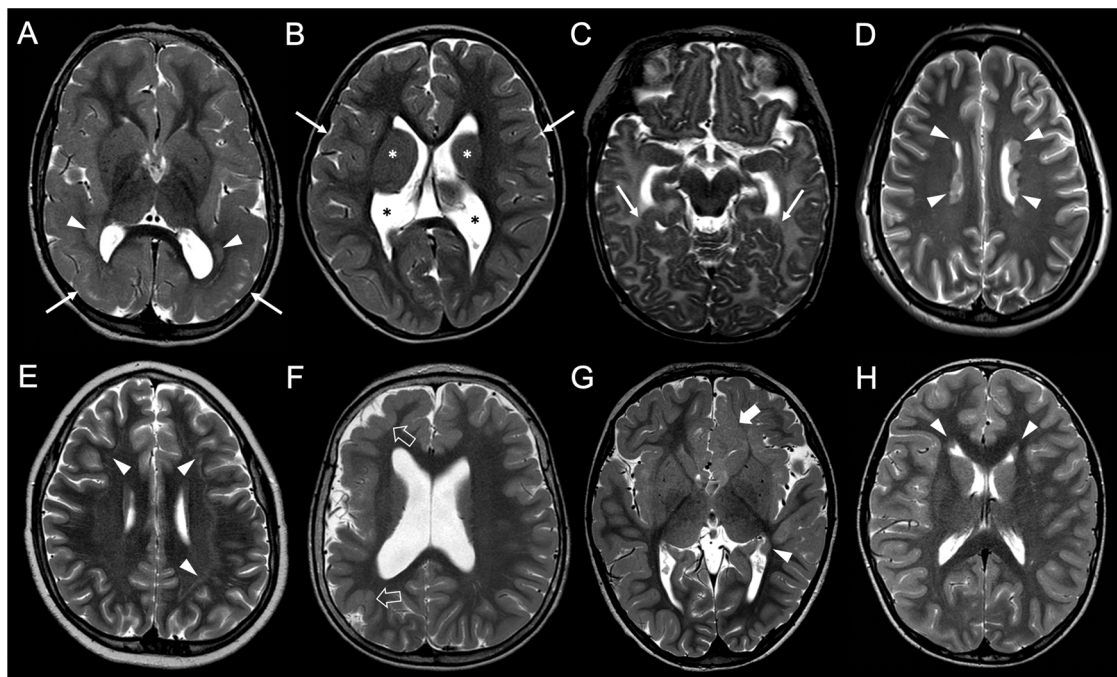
Brain MRI axial T2-weighted images of patients with positive (A–D) and negative (E–H) results at NGS panel. A) In this subject (S7) harbouring a *DYNC1H1* variant, there is bilateral diffuse lissencephaly with a posterior-anterior gradient (arrows) and nodules of heterotopic neurons in the temporal lobes white matter (arrowheads). B) Subject 5 harbouring a *TUBB3* variant present bilateral diffuse dysgyria, especially at the level of the insular lobes (arrows), associated with basal ganglia anomalies (white asterisks) and enlarged/dysmorphic lateral ventricles (black asterisks). C) In this subject (S17) carrying a *LAMA2* variant, bilateral focal cobblestone malformation is noted at the level of mesial temporal lobes (arrows). D) In this girl (S18) harbouring an *FLNA* mutation, there are bilateral multiple nodules of heterotopic neurons along the lateral ventricles (arrowheads). E) This patient with negative results at NGS panel (S70) presents with bilateral incomplete and subtle subcortical band heterotopia (arrowheads). F) Similarly, in this subject with unilateral diffuse polymicrogyria (empty arrows) and reduced hemispheric volume (S49), no pathogenetic variants are found. G) This subject with multiple but focal MCD (S56), i.e. left frontal polymicrogyria (arrow) and a single periventricular nodular heterotopia (arrowhead), the NGS panel yields negative results. H) In this subject with negative NGS panel (S78), there are few bilateral periventricular nodular heterotopias located only at the level of frontal horns (arrowheads).
